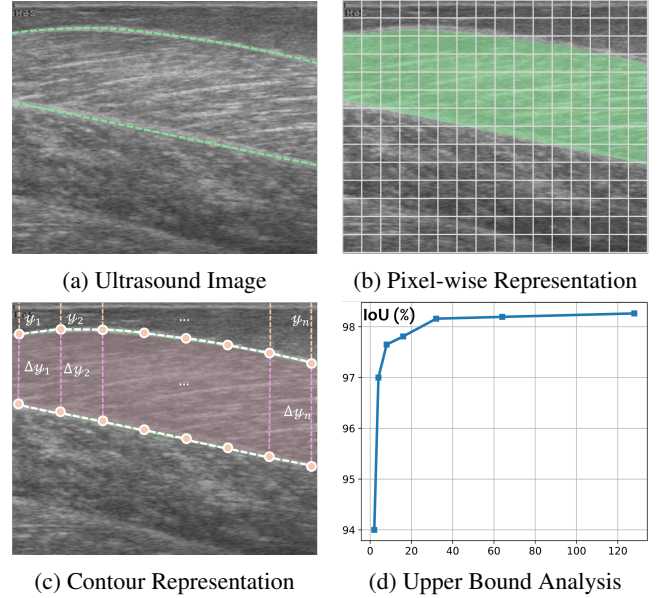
Segmentation with different mask representations. (a) is the original ultrasound image, where band-shaped muscle with annotated superficial and deep aponeurosis (green). (b) is the pixel-wise mask representation. (c) is our proposed contour representation. (d) is upper bound analysis. The 2d contour coordinates are sampled with Eq. 2. The higher the sampling number  $N$ , the more detail is preserved. Even small settings yield good approximations of non-linear muscle shapes, and result is saturated with  $N = 128$ .
